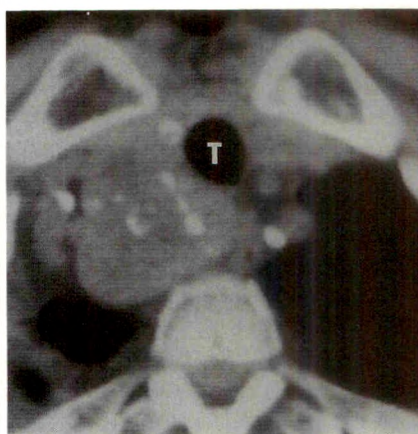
Neuroblastoma. CT scan shows large left posterior mediastinal mass extending into spinal canal (arrowheads) and destroying posterior rib. Calcification within mass (arrows). T = thymus.
